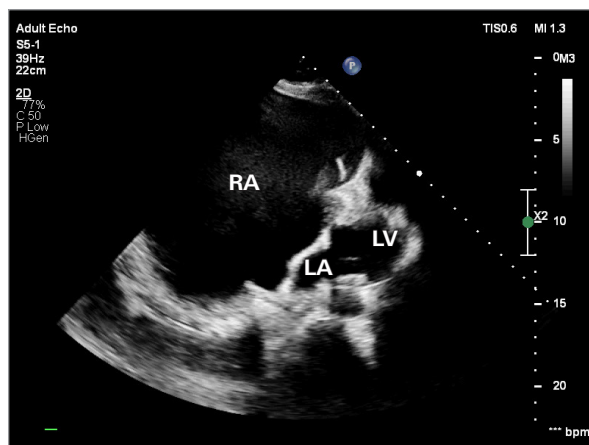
Transthoracic echocardiogram 4-chamber view showing a markedly enlarged right atrium with spontaneous contrast.
